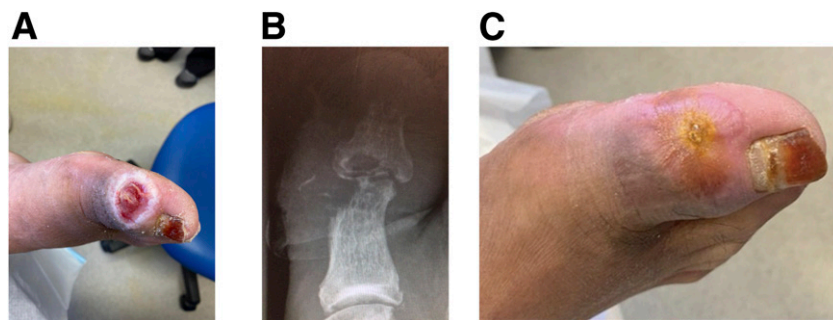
Images from case 1. *A*: Foot ulcer on medial side of right hallux prior to lockdown. *B*: Radiograph of right hallux prior to lockdown showing extensive osteomyelitis and septic arthritis in both phalanges and interphalangeal joints. *C*: After 8 weeks of antibiotics, 6 weeks post-lockdown showing healed wound on right hallux.
